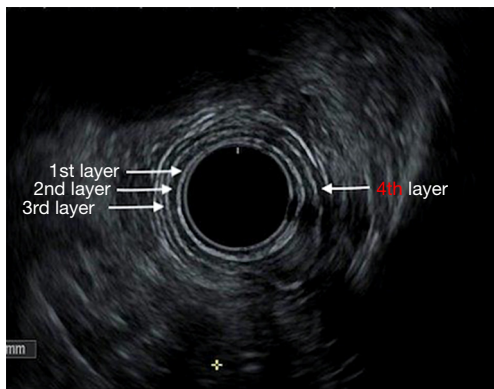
EUS depiction of esophageal layers. Layer 1: mucosa; layer 2: muscularis mucosa; layer 3 submucosal; layer 4: muscularis propria. EUS, endoscopic ultrasound.
